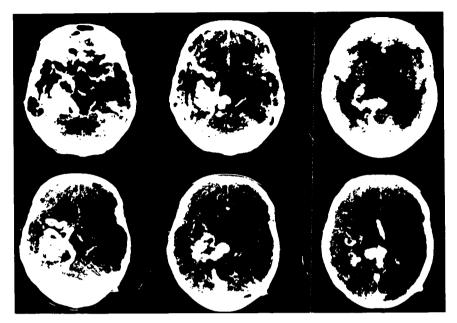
(Upper) CT scan on admission showing both an extensive arteriovenous malformation in continuity with the enlarged vein of Galen and an acute obstructive hydrocephalus. (Lower) Repeat CT scan showing shrinkage of the malformation and successful drainage of the hydrocephalus.
